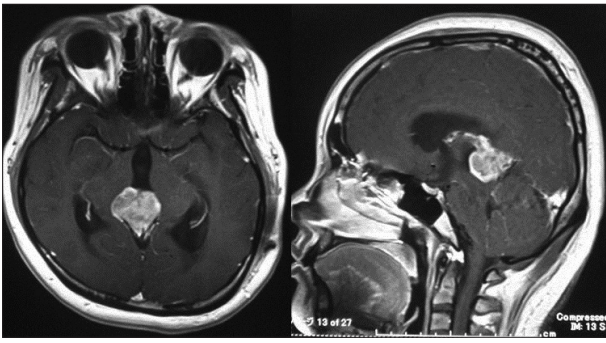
Preoperative enhanced magnetic resonance images revealing a heterogeneous enhancement of a pineal tumor with obstructive hydrocephalus.
